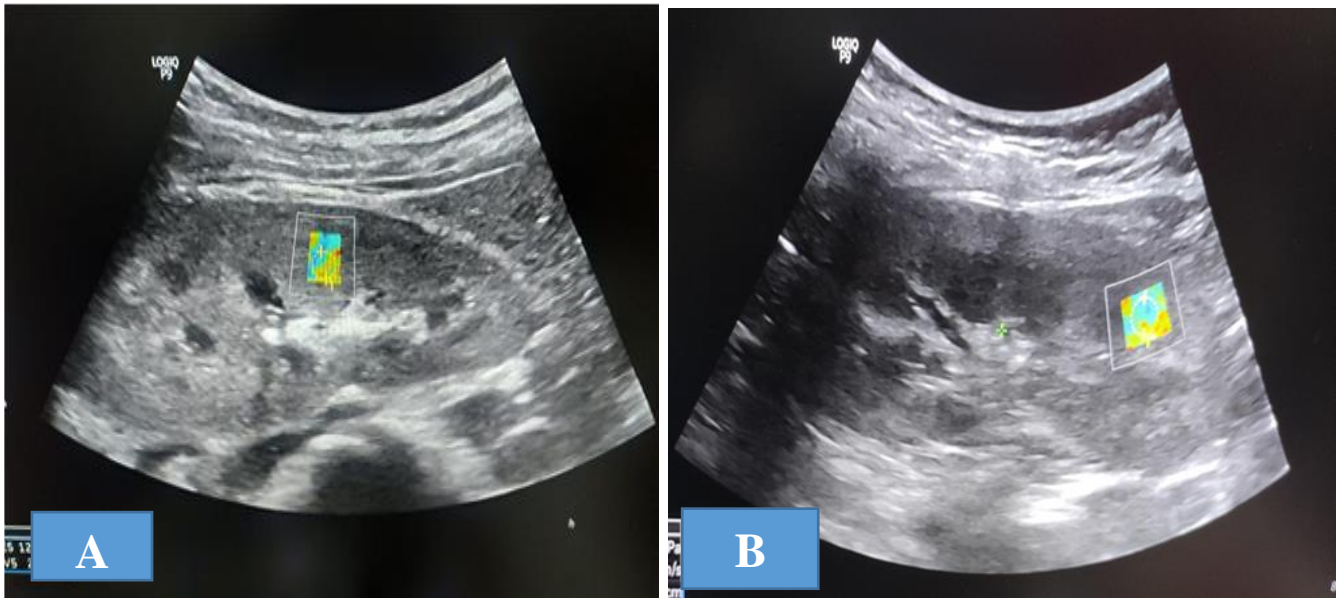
(A) and (B) showed right and left renal shear wave speed as evaluated using a 2D SWE. GE on a LOGIQ P9-General Electric ultrasound system.
